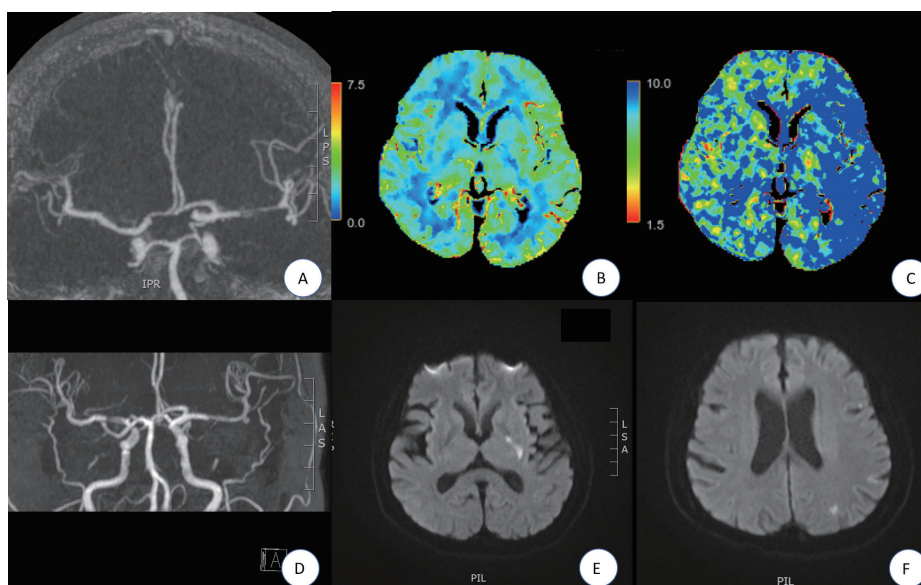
Brain CT and MRI findings of the patient
